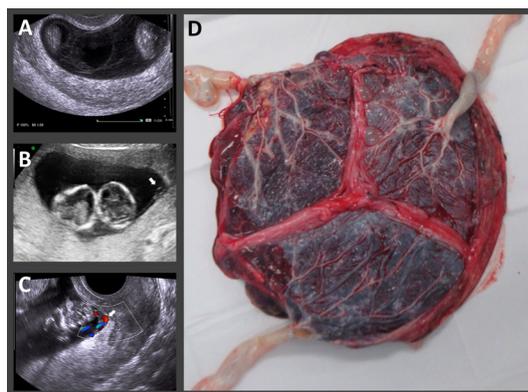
(A) A monochorionic-triamniotic triplet pregnancy diagnosed at week 9 of gestation. (B) Marginal insertion of the cord was observed in one fetus via transabdominal ultrasound, and (C) velamentous insertion of the cord was observed in another fetus via transvaginal ultrasound at week 13 of gestation. (D) Gross view of the placenta. The placenta was visibly divided into three equal parts by amniotic membranes with an appearance similar to a Mercedes-Benz logo. Marginal insertion in one fetus and velamentous insertion of the umbilical cord in another fetus were observed, which were comparable to the prenatal ultrasound findings at week 13 of gestation.
